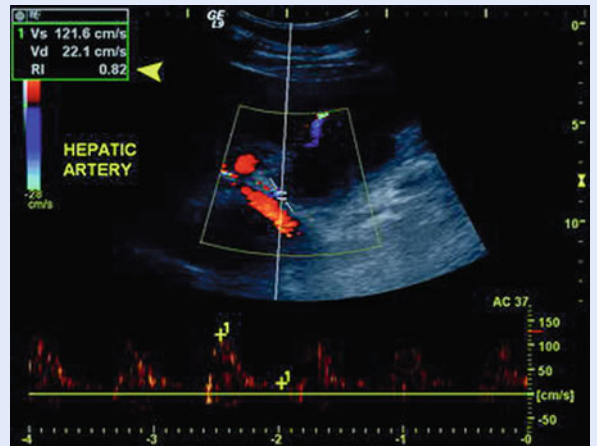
Hepatic artery color Doppler waveform spectrum in a patient with alcoholic liver cirrhosis shows high RI (arrowhead)
